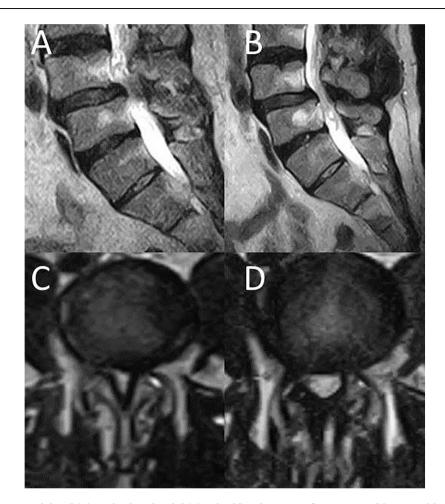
Pre-operative T2-weighted (A) sagittal and axial (C) spinal lumbar MRI of a 56-year-old man with a L4–L5 stenosis and spondylolisthesis. The patient was submitted to minimally invasive decompression at this level. One year FU T2-weighted sagittal (B) and axial (D) spinal lumbar MRI showing the optimal decompression of dural sac and nerve roots with no change of the degree of spondylolisthesis.
